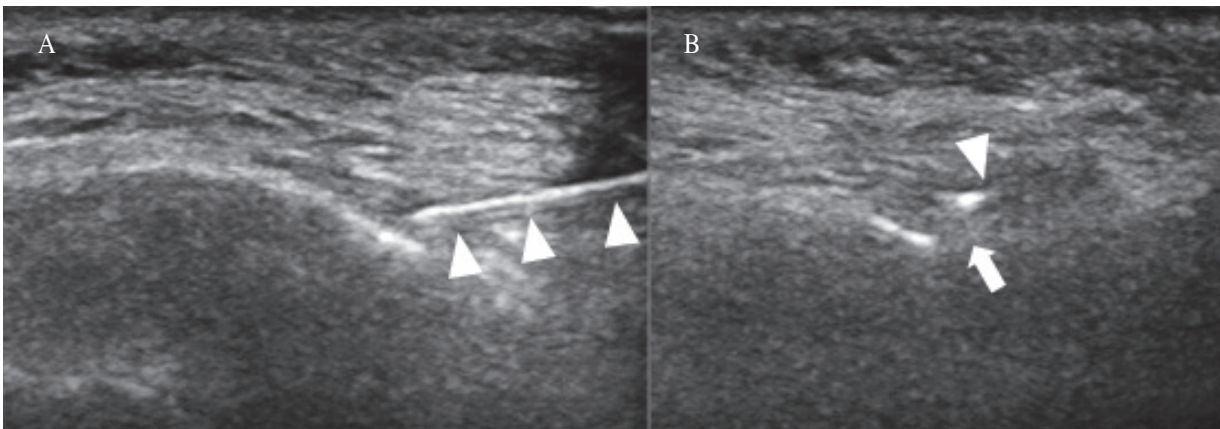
An ultrasound image of the block needle with longitudinal (A) and transverse (B) view. The needle through the supraorbital notch is indicated with arrow heads. The supraorbital nerve is shown just below the needle with an arrow.
